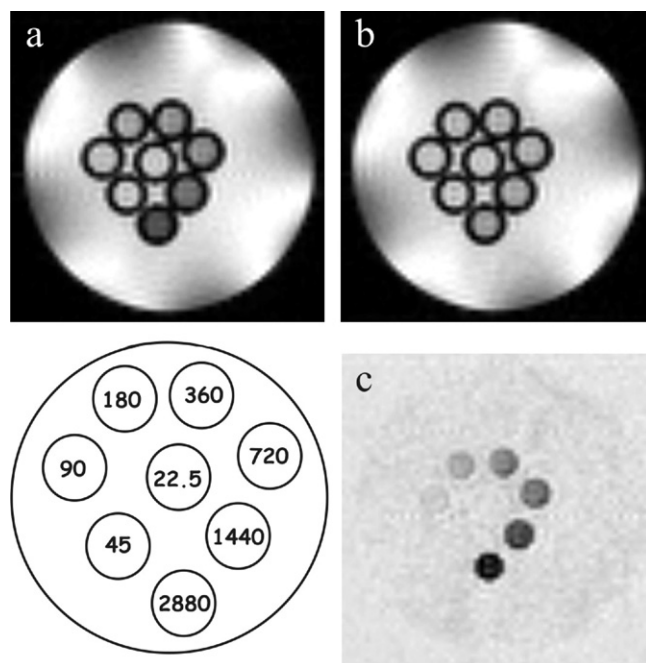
MRI-CEST images of eight capillaries containing different concentrations of a LIPOCEST agent entrapping [TmDOTMA] $^-$ (7 T, 312 K, saturation scheme: 120 sinc3 pulses 25 ms each, interpulse delay 10 μ s, B_2 intensity 12 μ T). (a) Image after saturation at 3.1 ppm. (b) Image after saturation at -3.1 ppm. (c) Image difference (a and b). Bottom left: concentrations of the agent in the capillaries. Adapted from ref. [88].
